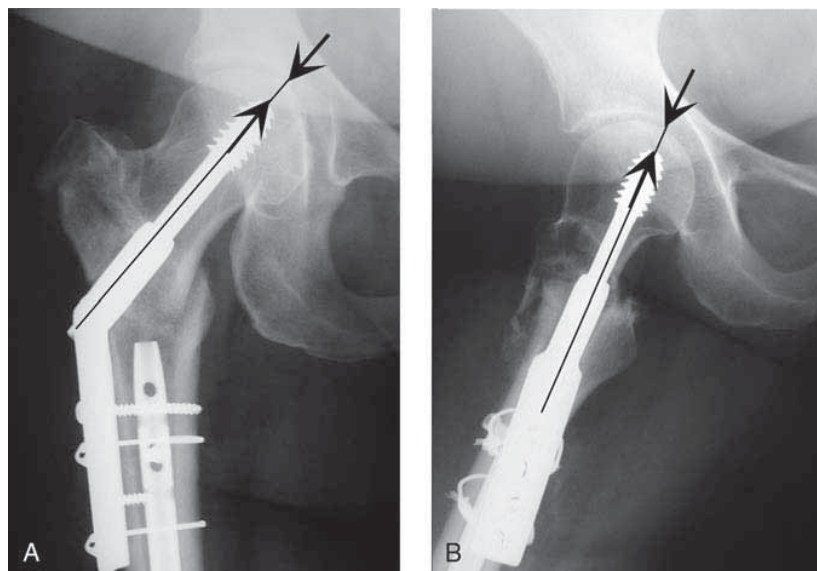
The distances from the tip of the implant to the apex of the femoral head on an AP (A) and a lateral (B) radiograph are combined to determine the tip-apex distance. Cutout failure generally is unlikely if the tip-apex distance is less than 25 mm.
